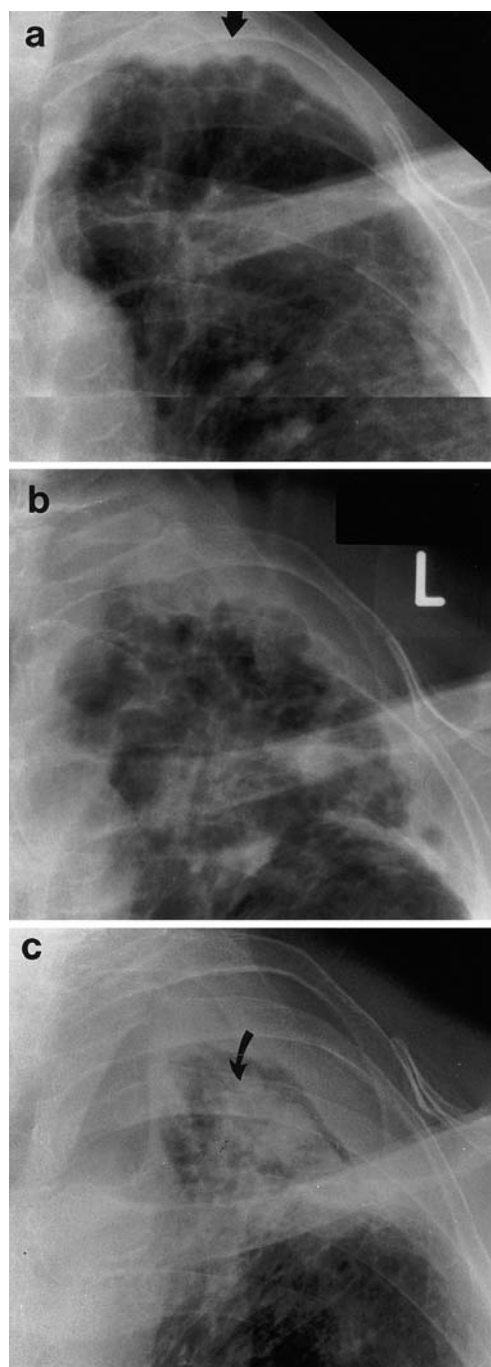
Evolution of aspergilloma on chest radiography. a Minimal pleural thickening at the left apex (*arrow*) in a patient with fibrotic lung disease. b Five years later, there is lateral pleural thickening but no obvious aspergilloma. c Ten years after a, there is an intracavitary aspergilloma (*arrow*) compatible and more extensive pleural thickening
